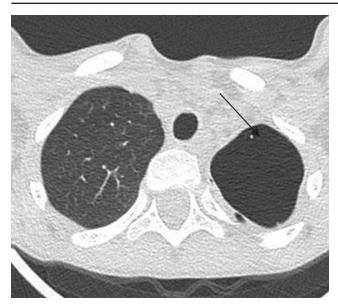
Pulmonary CT- Air cysts in the right pulmonary parenchyma with fibrous walls. 14-year-old child with FC, chronic Ps. aeruginosa pulmonary infection, CFTR genotype G542X/N1303K
